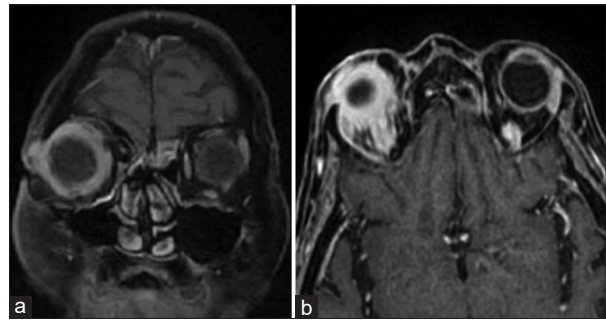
Magnetic resonance imaging with medical dye contrast. (a) Supero-lateral abscess. (b) Optic neuritis
